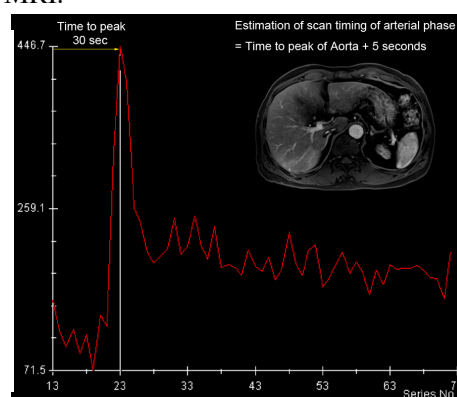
Estimation of scan timing of routine 4-phase MRI using time-intensity curve obtained from test-bolus DCE-MRI.
